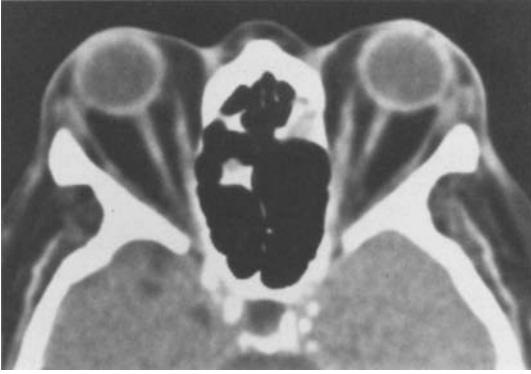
Patient with a long duration of disease. The CT reveals a striking protrusion of both bulbs but no enlargement of the muscles. An increase of the retrobulbar fat must be presumed.
